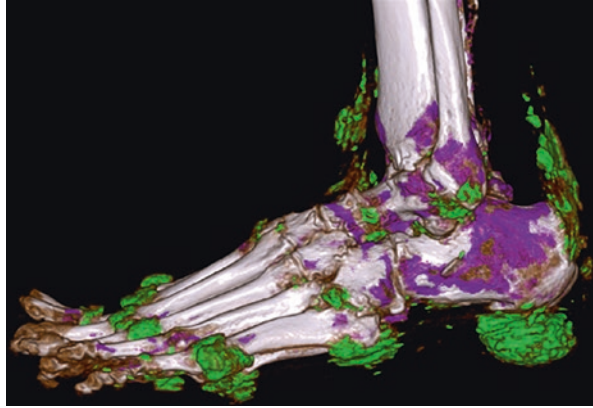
Dual energy computed tomography in a patient with gout. Numerous green-coloured tophi are seen over MTP joints and foot entheses (Achilles tendon, digits extensor tendons and plantar fascia)
